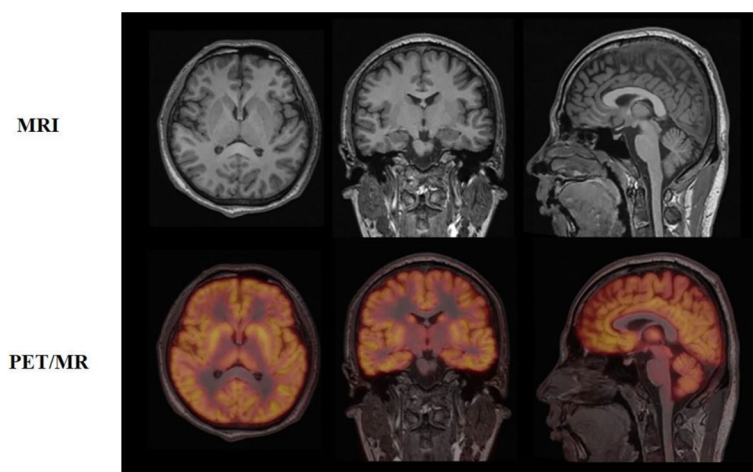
[^{18}F] SynVesT-1 PET/MR imaging of brain
